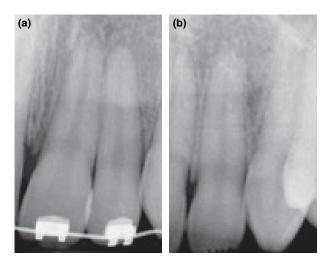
(a) The left central maxillary incisor of a 12-year-old boy was slightly luxated palatally, with the orthodontic appliance preventing severe dislocation. (b) The 4-year follow-up radiograph shows normal findings.
